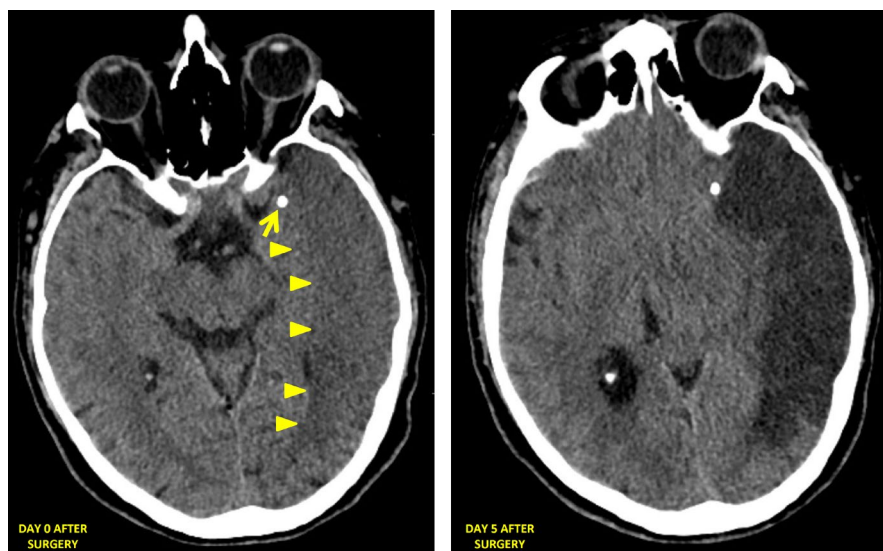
Computed tomography on the onset of symptoms (left) and 5 days later (right)
